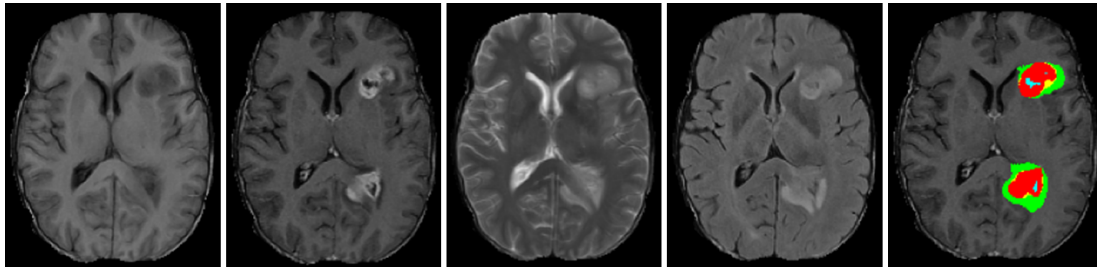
Examples of segmentations in the Challenge data set (subject id: 310). From left to right: T1, T1c, T2, FLAIR, and the segmentation. Each color represents a tumor class: green – edema, blue – necrosis, yellow – non-enhancing tumor, and red – enhancing tumor.
